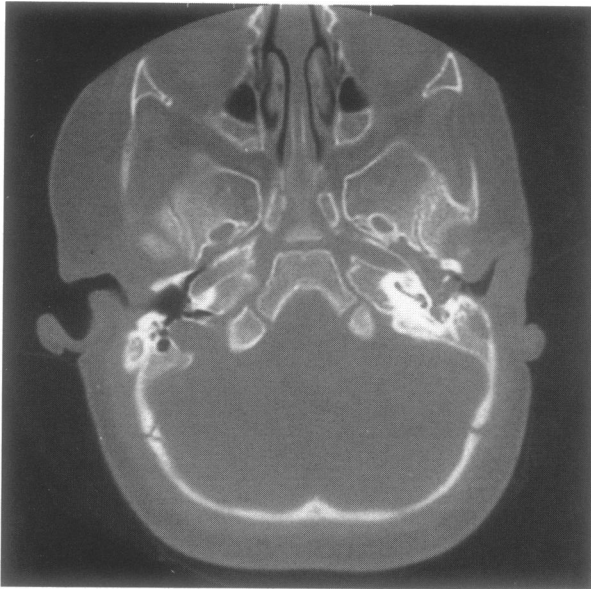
Axial CT of the skull base showing left middle ear opacification and expansion of the proximal one third of the eustachian tube.
